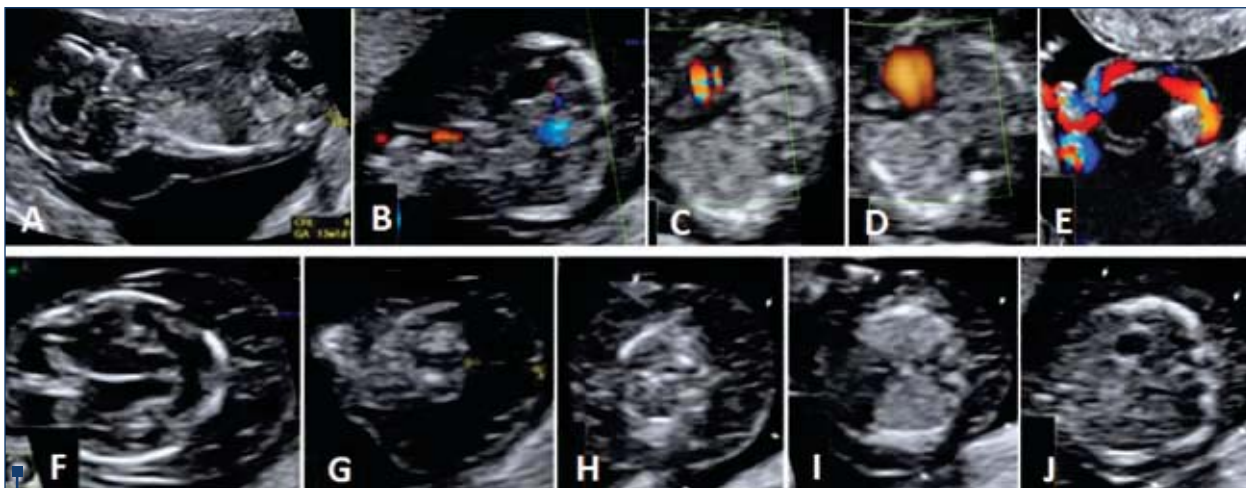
Turner (XO) syndrome in fetus presenting cystic hygroma at 13 weeks. Severe edema is visualized in sagittal global view (A), and transverse views of the head (F), neck (G), thorax (H, I) and abdomen (J). Omphalocele (B) and umbilical cord cyst (E) were also noted. C: Color Doppler at the level of the four-chamber view demonstrating filling of the both left and right ventricles during diastole, confirming the patency of the atrio-ventricular valves; a diminutive left ventricle was remarked. D: Power Doppler at the level of the four-chamber view; a narrow width of the left ventricle in comparison to that of the right ventricle was confirmed, and a hypoplasia of the aortic arch was further suspected, cardiac anomaly which is sometime associated with Turner syndrome
